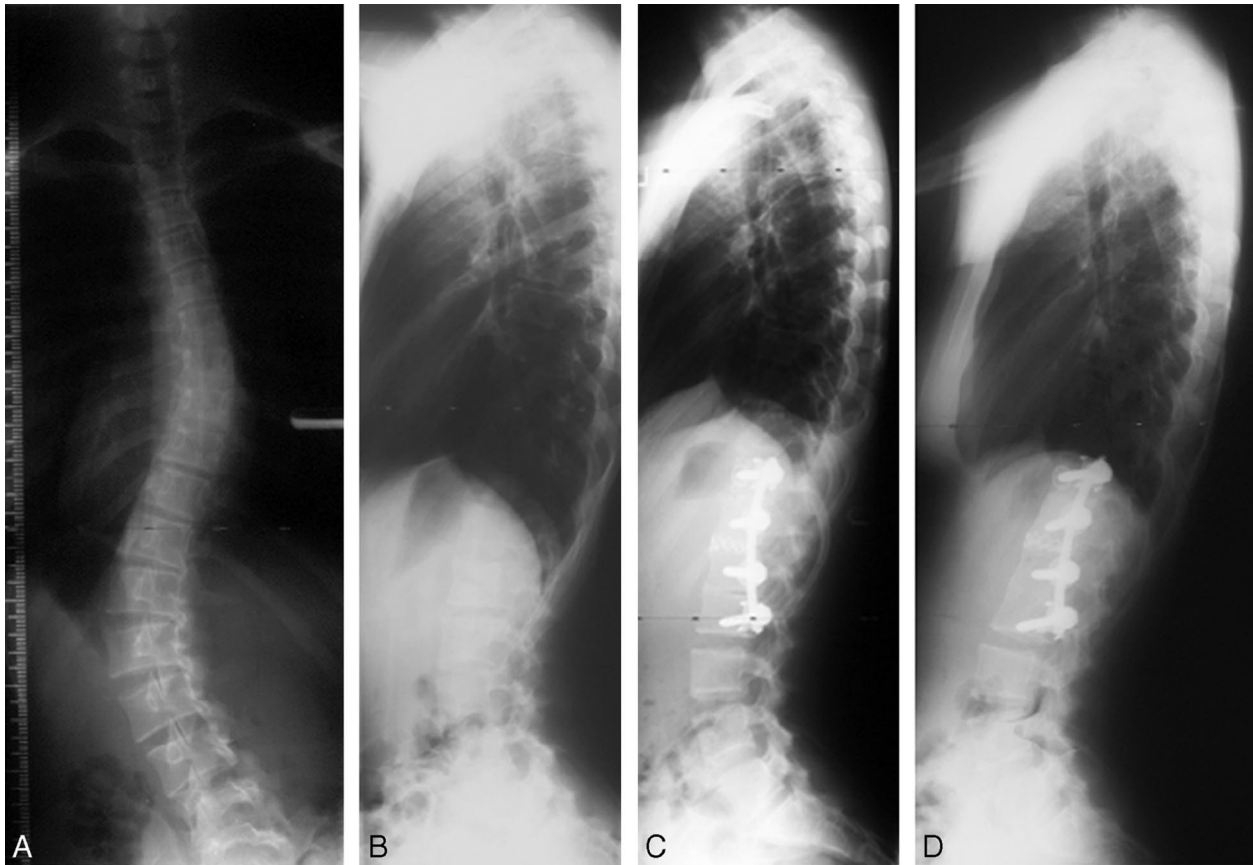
(A) Preoperative AP radiograph. Thoracolumbar primary curve with a Cobb angle of 48° from T11–L3. (B) Preoperative lateral radiograph. Lordosis from T12–L3 (future LIV) is -7° , lordosis below to be instrumented levels (LIV–S1) is -39° , and lateral plumb measures -10 mm. (C) Postoperative lateral radiograph. There is a loss of lordosis from T12–LIV to -1° , lordosis below the instrumentation remains at -41° , and lateral plumb shifts slightly anteriorly to -5 mm. (D) Follow-up lateral radiograph. The lordosis from T12–LIV is -4° , the lordosis below the instrumentation increases to -52° , and the lateral plumb shifts posteriorly to -36 mm.
